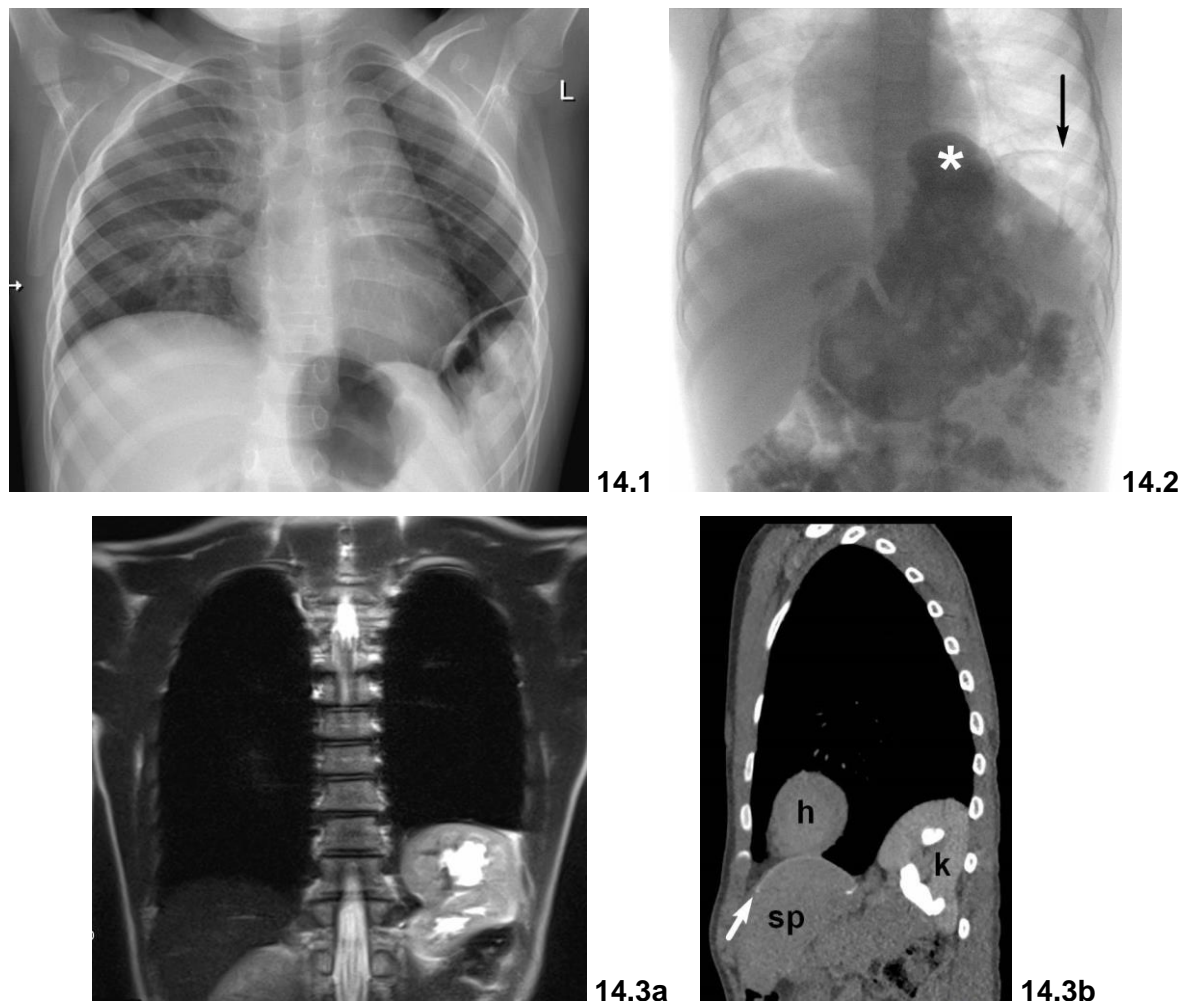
radiological diagnosis of diaphragmatic complications (14.1 plane chest X-ray in a 2-year-old boy: lateral recurrence; 14.2 contrast-study in a 4-year-old boy: hiatal hernia (*) and lateral recurrence (→); 14.3 MRI (a) and lowdoseCT (b) in a 10-year-old girl with thoracic herniation of the left kidney (CT-scan (b): h=heart, k=kidney, sp=spleen, cone-shaped patch marked with white arrow))
